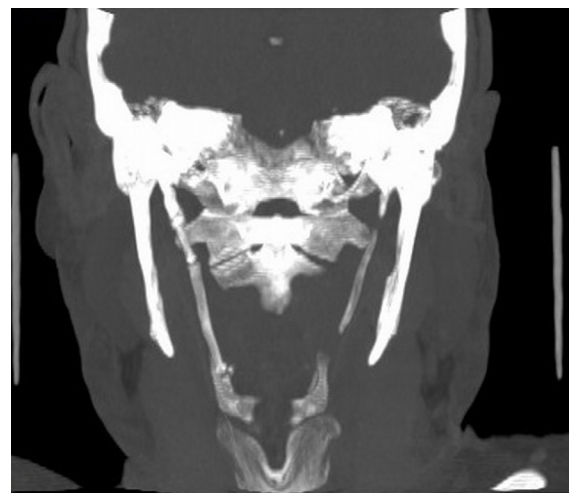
The axial computed tomogram shows complete ossification of the stylohyoid ligament on the right side, with partial ossification on the left side.
